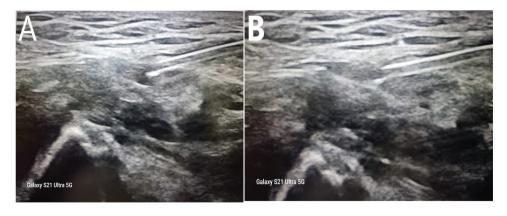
Ultrasound guided suprainguinal fascia iliaca block. Ultrasound scans: SIFI block pre-injection (A) and post-injection (B).
